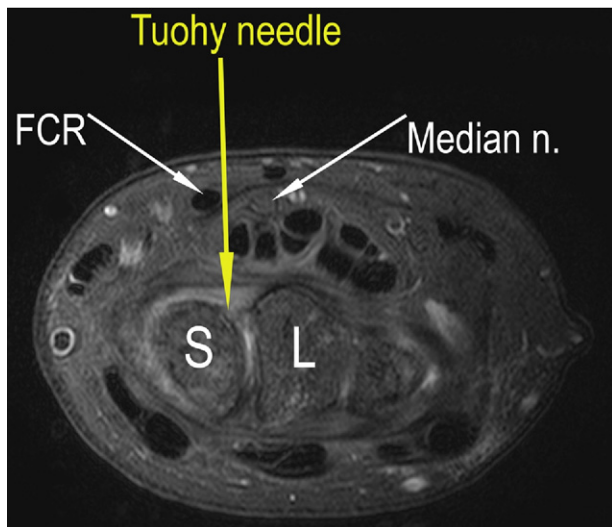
Magnetic resonance image at the corresponding level of the repair.
